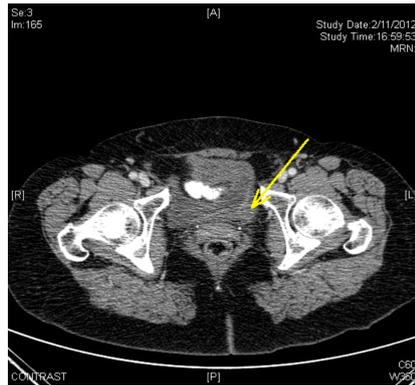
Abdominal CT scan with contrast. Yellow arrow showing a 16 mm tumor in the posterolateral bladder wall, surrounding the left ureteral meatus.
